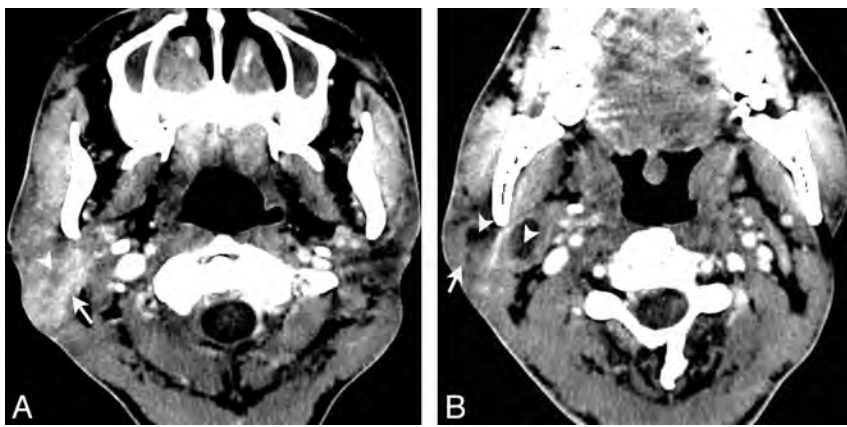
LEC of the right parotid gland in a 38-year-old man with painless masses in the right parotid regions for approximately 3 years. Axial contrast-enhanced CT (A) shows an ill-defined mass located in the right parotid gland (arrow) with heterogeneous enhancement and much intratumoral necrosis (arrowhead). Axial contrast-enhanced CT (B) shows multiple enlarged nodes (arrow) in the intraparotid region and level IIa, with obvious necrosis (arrowhead).
